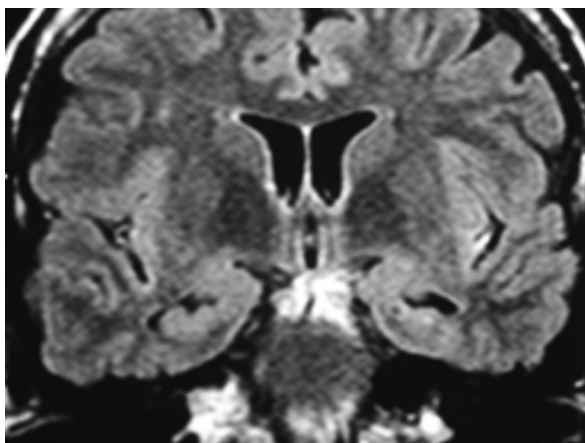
MRI coronal Flair showing atrophy/hyperintense left hippocampus and amygdala.
